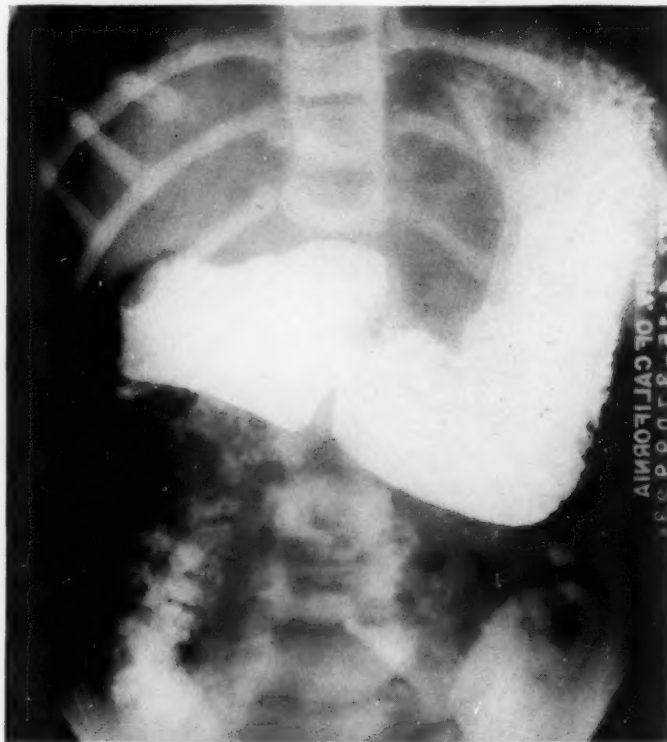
Case 2: Radiograph three hours after barium meal showing dilated stomach and megaduodenum with obstruction.
